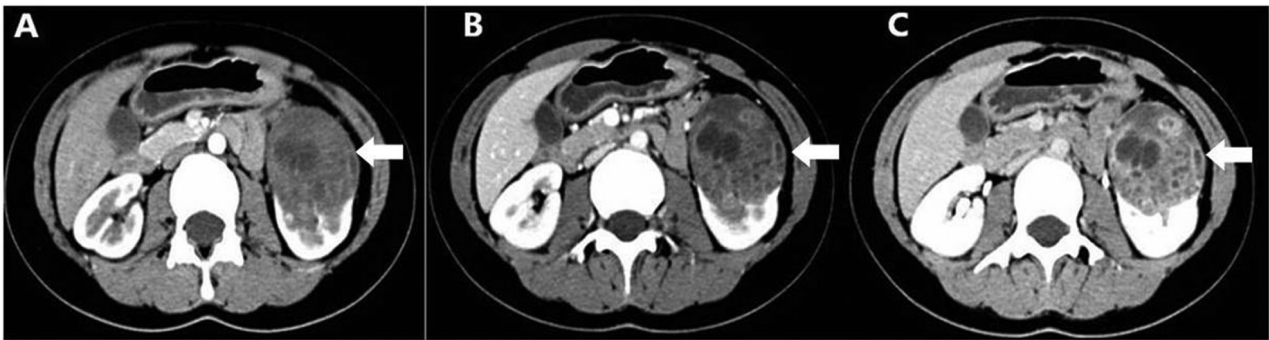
Axial enhanced abdominal CT imaging (A-C): a mass of 46×56×81 mm in the lower pole of the left kidney (arrow) that was composed of solid and cystic components. A heterogeneous delayed enhancement was found in this mass.
